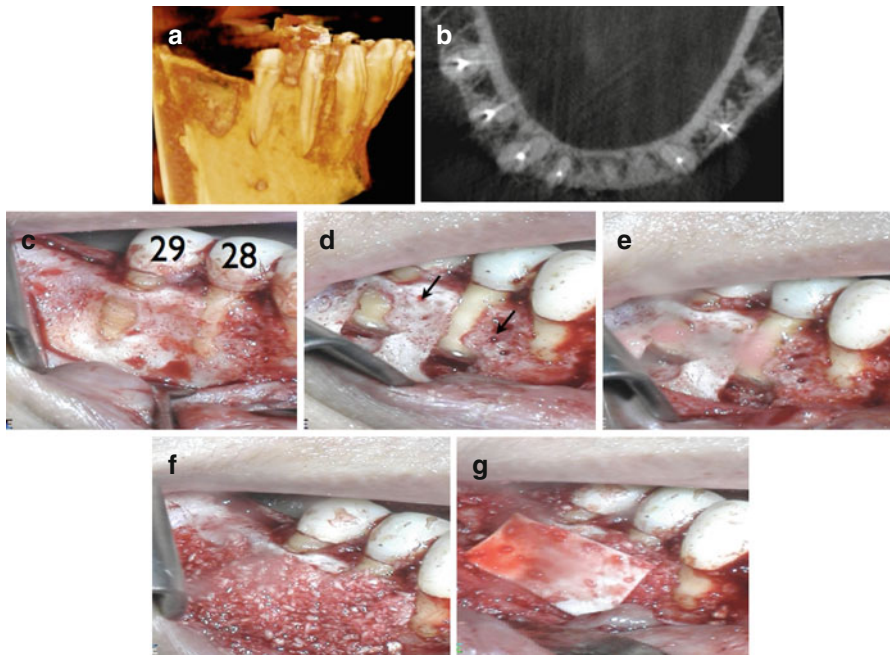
3D CBCT rendering and axial view of teeth #28 and #29 that were referred for apical surgery (a, b). Complete dehiscence of the root of tooth #28 and fenestration of tooth #29 was observed. Clinical picture after surgical flap reflection confirming the CBCT findings (c). Root-end resection, conditioning, and root-end filling with MTA. Size #2 round bur cortical holes were placed (black arrow) for the rapid acceleration phenomenon (RAP) to ensure blood supply to the bone graft (d, e). Periodontal and periapical defect grafted with enCore™ combination (70% cortical and 30% cancellous) from Osteogenics Biomedical Lubbock, TX. CopiOs™ membrane (Zimmer Dental, Warsaw, IN) was placed over the grafting material (f, g)
